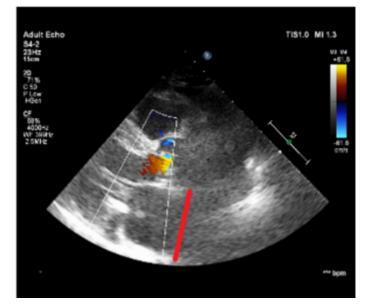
Bidimensional echocardiography. Parasternal long axis view. Left atrial diameter measurement.
